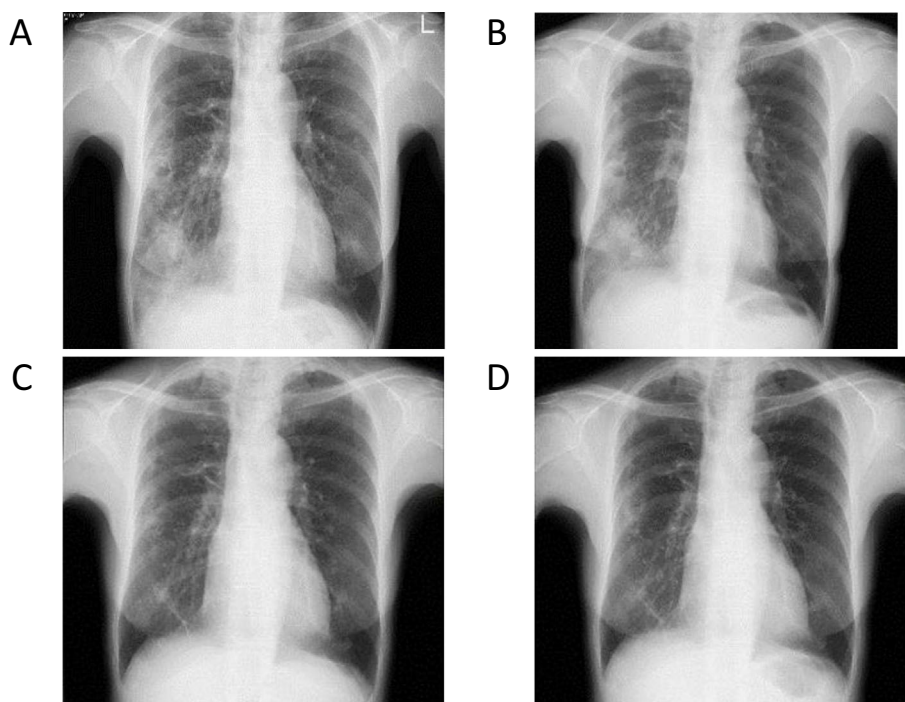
Chest X-ray on admission to our hospital showed infiltration shadows with cavities (arrow) in the middle and lower lung fields and left lower lung fields (A). Chest X-ray after one month revealed a slight improvement (B), that after six months revealed the marked improvement of infiltration shadows with cavities in the right middle and lower lung fields and left lower lung fields (C), and that after one year revealed no notable changes (D).
